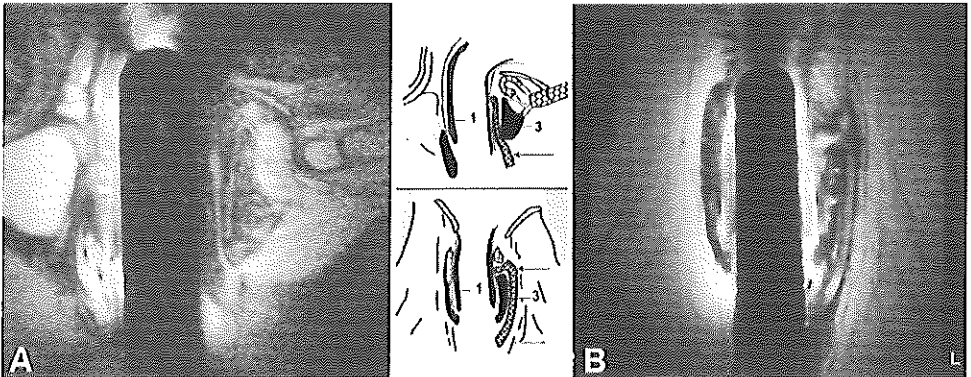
Intersphincteric versus transsphincteric fistula*. MR images. Intersphincteric fistula(A) (arrow) running between the internal (1) and the external (3) sphincters, whereas the transsphincteric fistula(B) (arrow) runs outside the external sphincter (3).
